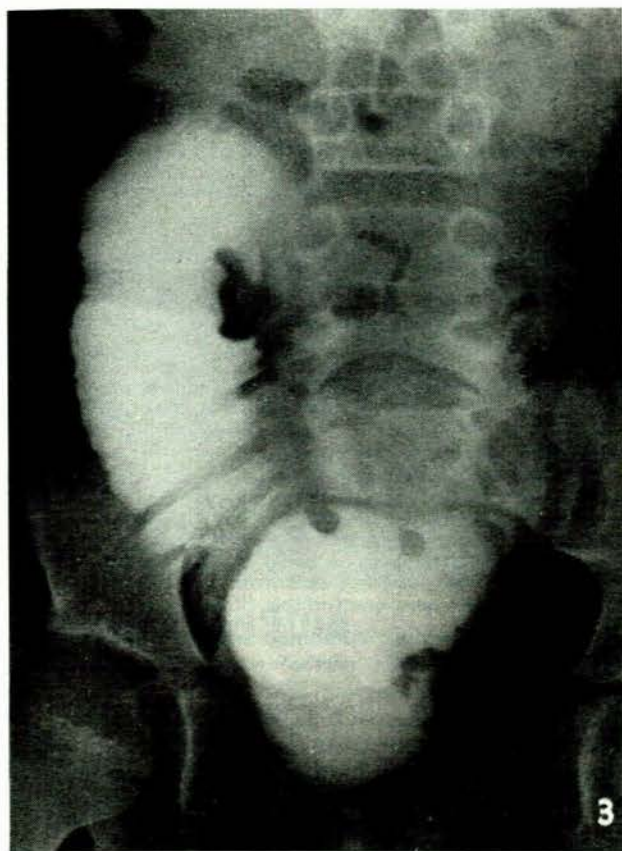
X-ray showing dilated, distended ileal conduit.
